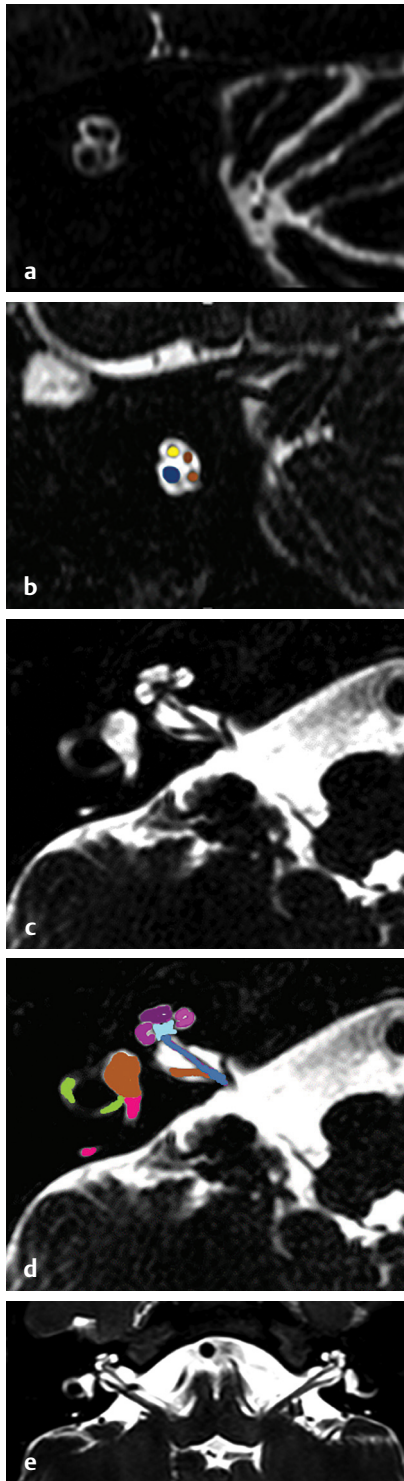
MRI CISS/FIESTA sequence, (a, b) oblique sagittal images at fundus of internal acoustic canal and (c, d, e) axial sections show normal cochlear nerve larger than facial nerve. (Yellow, facial nerve; brown, superior vestibular nerve above and inferior vestibular nerve below; blue, cochlear nerve; Pink - posterior SCC, Purple - apical turn of cochlea, Dark Pink - middle turn of cochlea, Light pink- basal turn of cochlea, Light green - lateral SCC, Light blue - modiolus, and Red arrow shows Rosenthal's canal (RC)).
